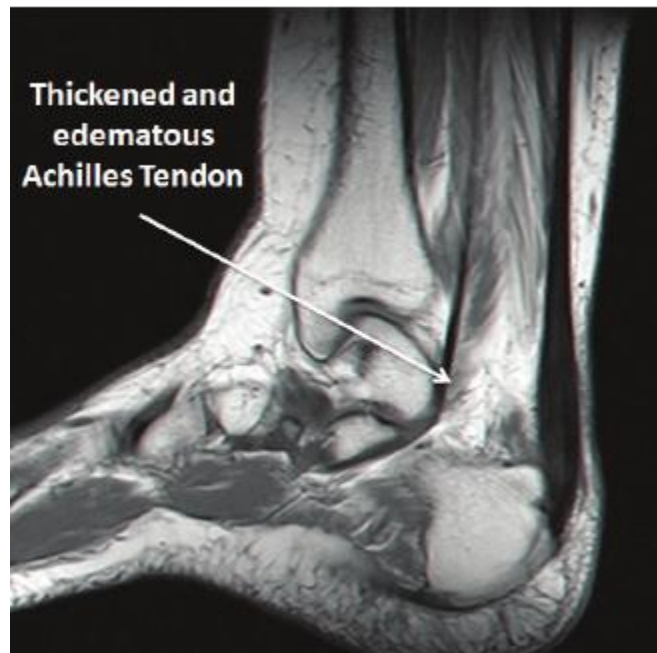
MRI showing thickened and edematous Achilles tendon.⁵⁷
